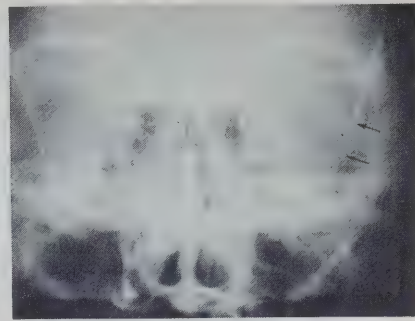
Case 3: Skull radiograph showing erosion of linea innominata on left side (arrowed).
